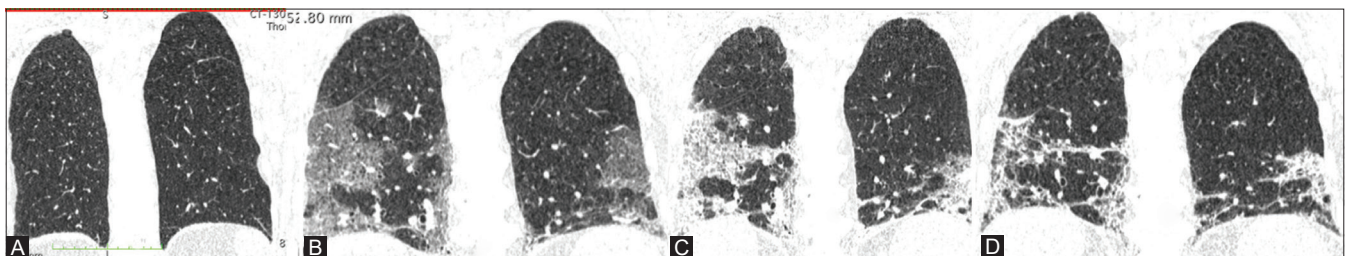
(A-D): Series of HRCT images in coronal plane demonstrating the evolution of COVID-19 pneumonia. HRCT (A) normal, HRCT (B) ground-glass densities, HRCT (C) consolidations with septal thickenings, HRCT (D) residual reticular opacities of organising pneumonia which with time should resolve
